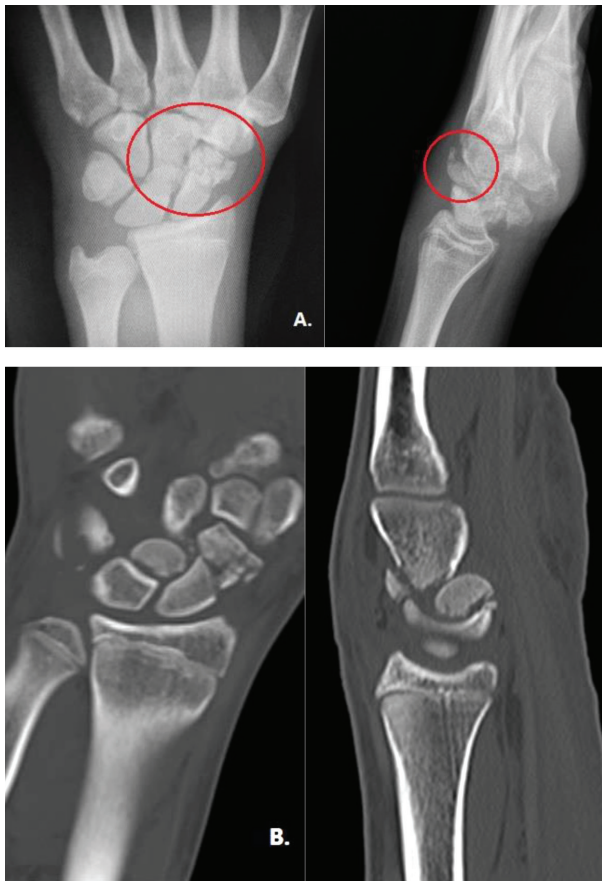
Preoperative standard radiographs (A) and CT scans (B) which show the fractures
